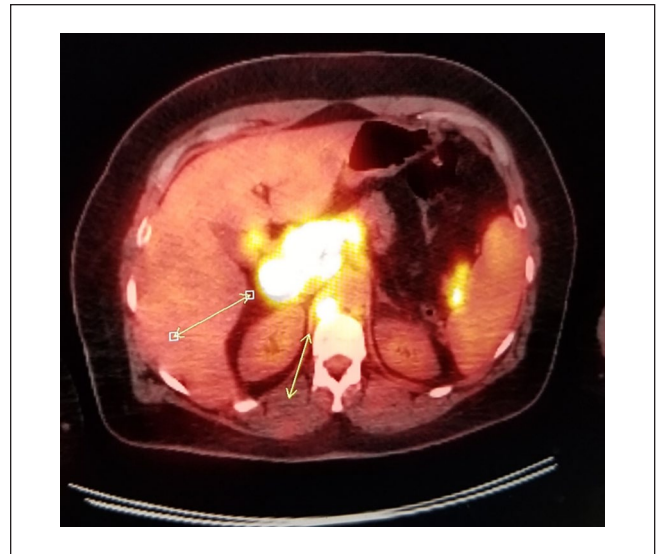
Widespread lesions on PET-CT highly suspicious for lymphoma/metastasis.
